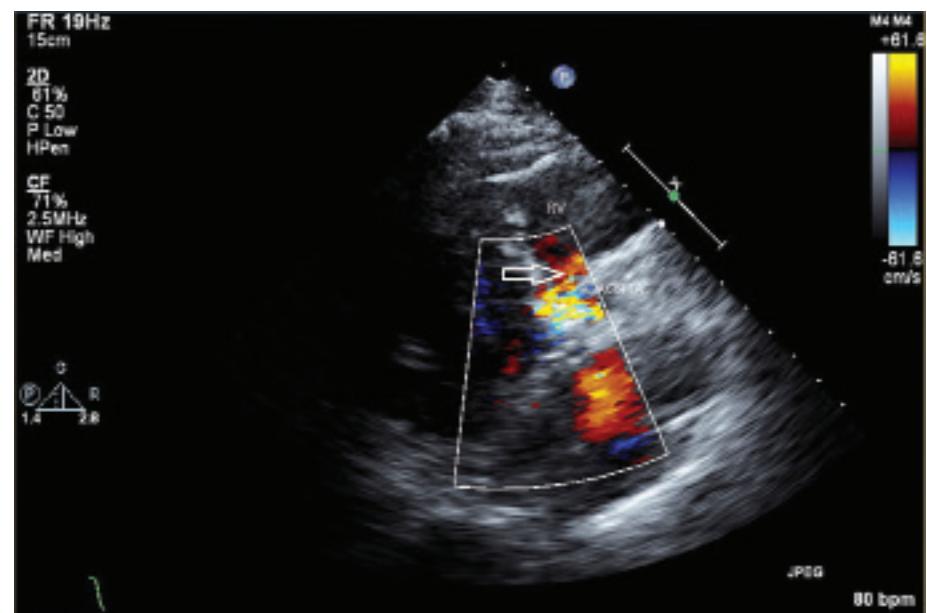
Parasternal long axis view demonstrating flow from aorta to right ventricle after CoreValve Evolut valve placement.
